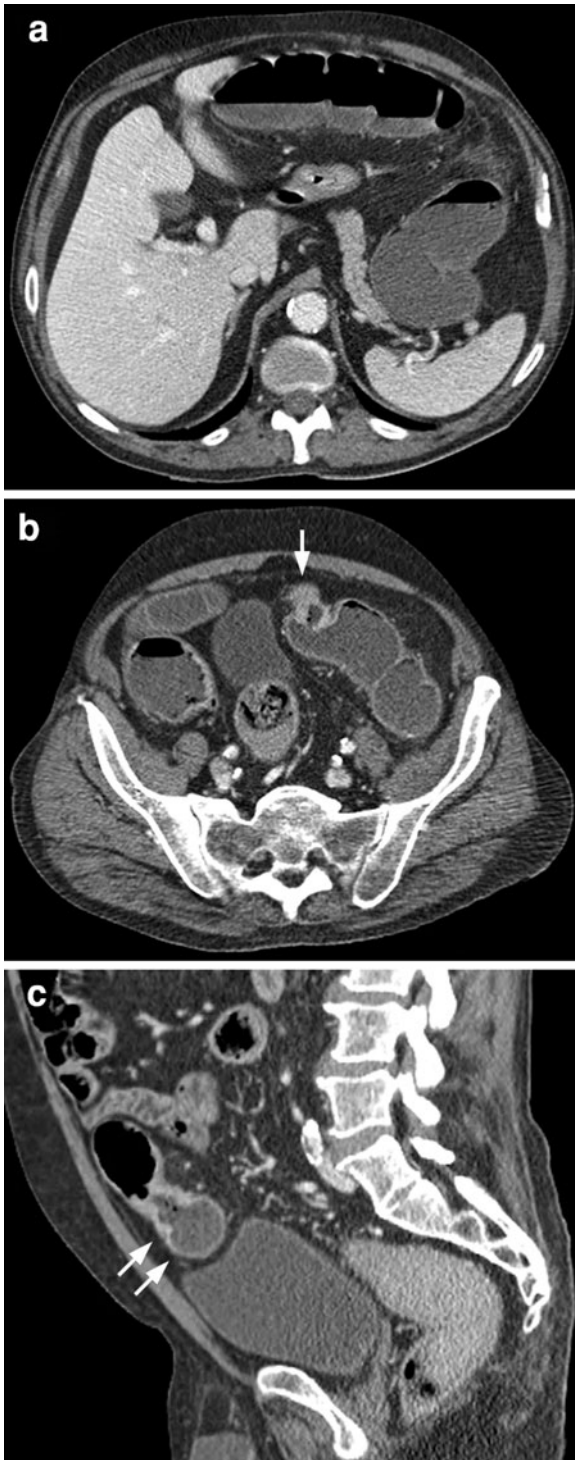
LBO due to ischemic colitis. Axial slices (a, b) show a colonic dilatation due to a short stenosis with a symmetric thickening of the sigmoid wall (arrow). Sagittal reformatting (c) shows distal colon which is not entirely collapsed (double arrows). The CT diagnosis was LBO due to cancer with the diagnosis of ischemic colitis revealed by surgery and pathologic analysis
